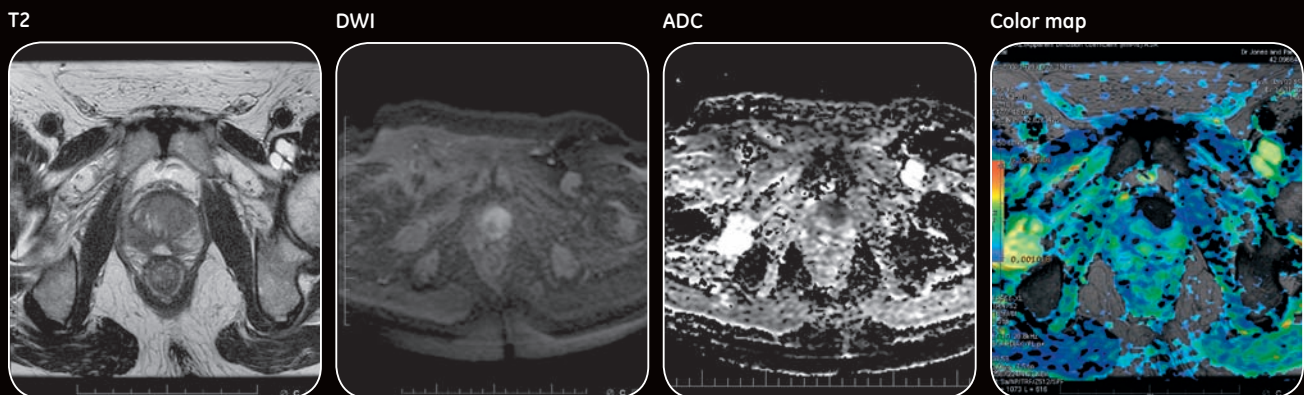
Patient history: PSA 15, Gleason 7 right apex and left mid gland biopsy. Several areas of abnormality noted. Peripheral zone complicated by post biopsy hemorrhage. Largest tumor nodule is located in the central gland, not seen on biopsy. With color map and ADC/DWI, tumor is well visualized with prominent restricted diffusion. Matching "erased charcoal" appearance seen on the T2.
